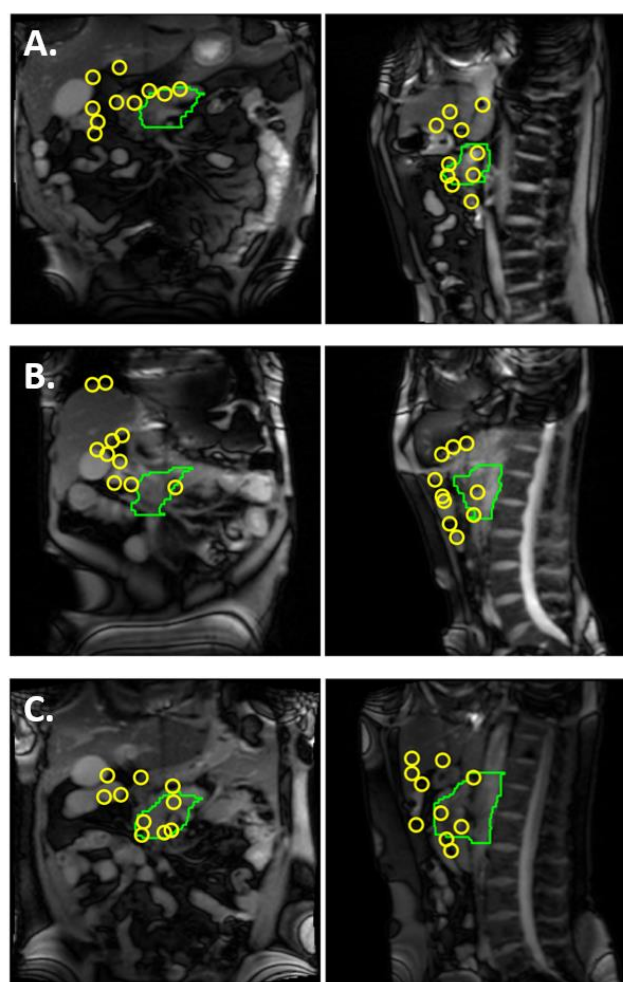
Figure s2. Coronal (left column) and sagittal (right column) cine-MRI frames with Clinical Target Volume contour (green) and selected anatomical landmarks (yellow circles). A. P02, B. P03, C. P04.
